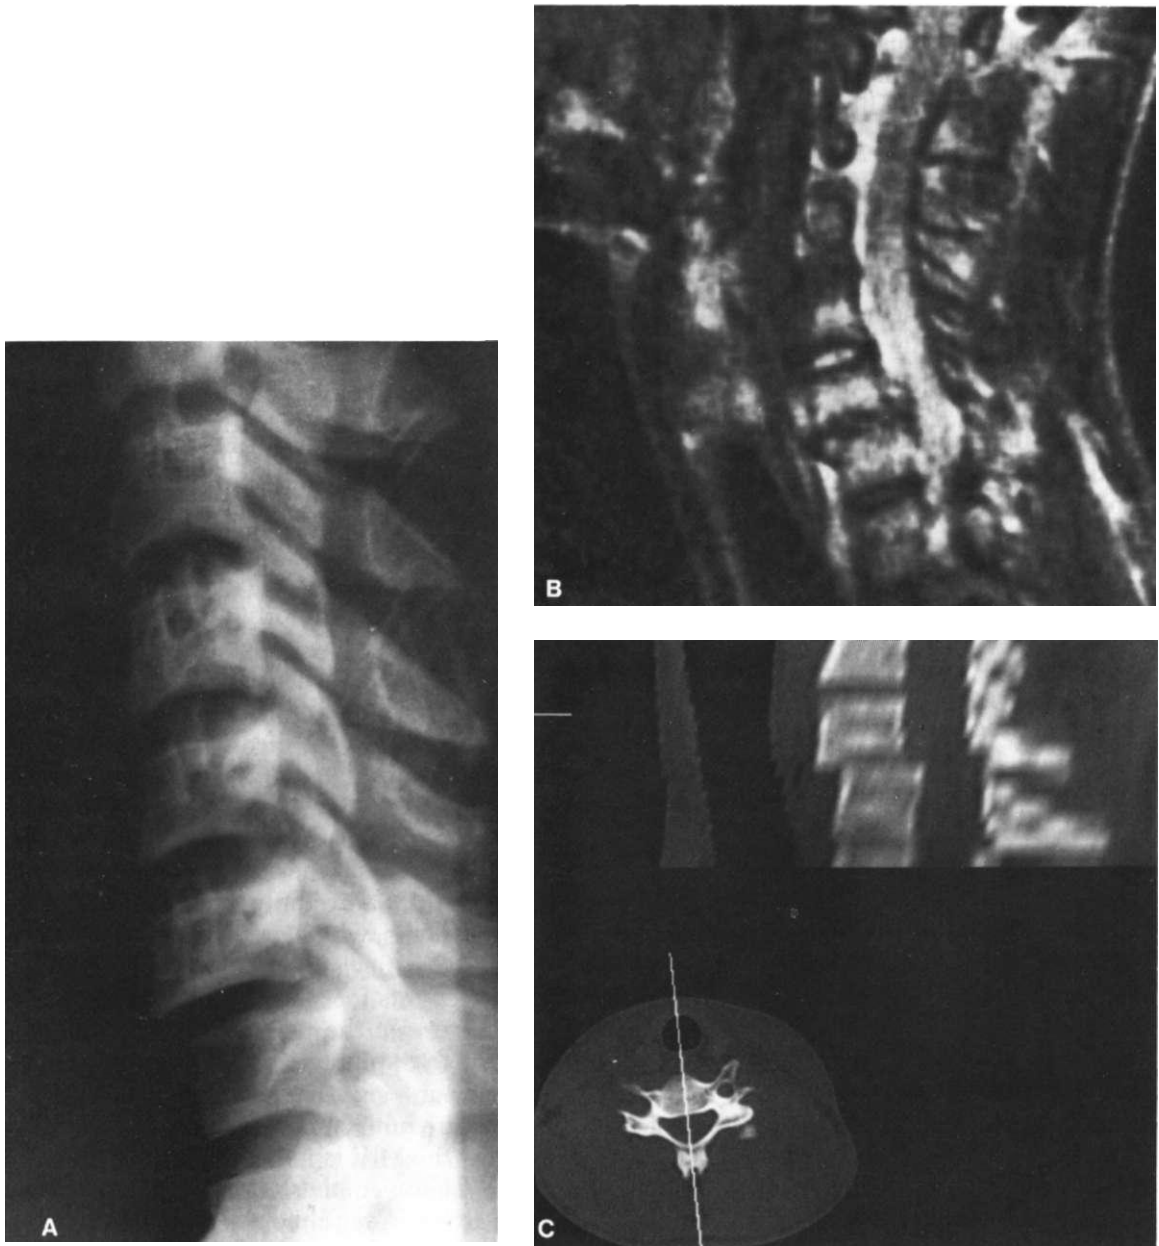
This is the important observation of Eismont and associates. (A) A post-traumatic unilateral C6–C7 facet fracture dislocation. The patient was neurologically intact. However, the patient was at risk to develop neurological deficit had there been an attempt at reduction. (B) An MRI image shows a large fragment of disc tissue in the canal and behind the body of C6. (C) The disc herniation may not have been visualized on CT scan. Unilateral and bilateral facet dislocations and fracture dislocations should have an MRI prior to attempts at reduction, unless there is already a complete neurological deficit. This patient was treated with anterior discectomy and fusion. Because this anterior approach further increases the instability, it must be followed with either a posterior fusion or, if reduction can be achieved, an anterior plate with screws. (CT and MRI images courtesy of Professor Frank Eismont, M.D.)
